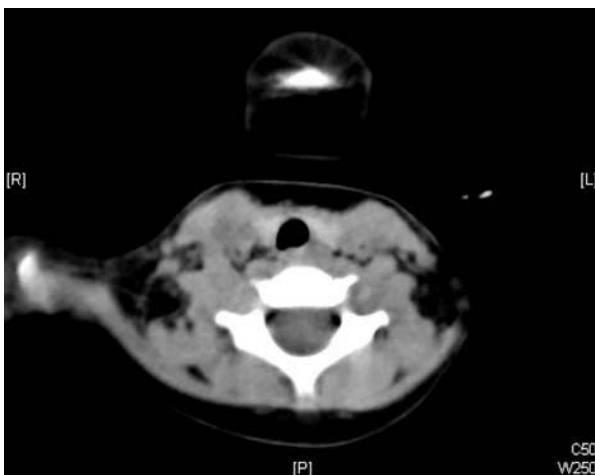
There was no abnormality in thyroid and parathyroid in CT neck.
